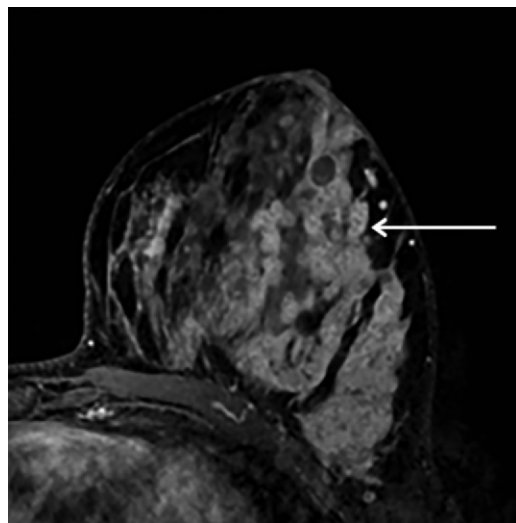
Clustered ring. This new term describes internal enhancement that previously was included in the term *reticular/dendritic enhancement*. Axial contrast-enhanced T1-weighted delayed MR image shows diffuse clustered ring enhancement (arrow) in a patient with biopsy-proven ductal carcinoma in situ.
